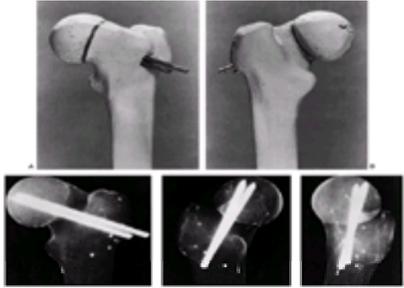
Models of a moderate slipped capital femoral epiphysis stabilized *in situ* with two threaded pins demonstrate the concept of the radiographic blind spot of the femoral head (A) and (B). This concept proposes that there will always be an area in the femoral head where a pin may violate the head itself, and yet not be seen on plain radiographs (C). The blind spot is smallest in the central axis of the femoral head, and increases greatly the farther the fixation device position is off the central axis. Only by positioning the fixation device centrally, and at least 5 mm from the margin of the femoral head, can avoidance of penetration be assured.
